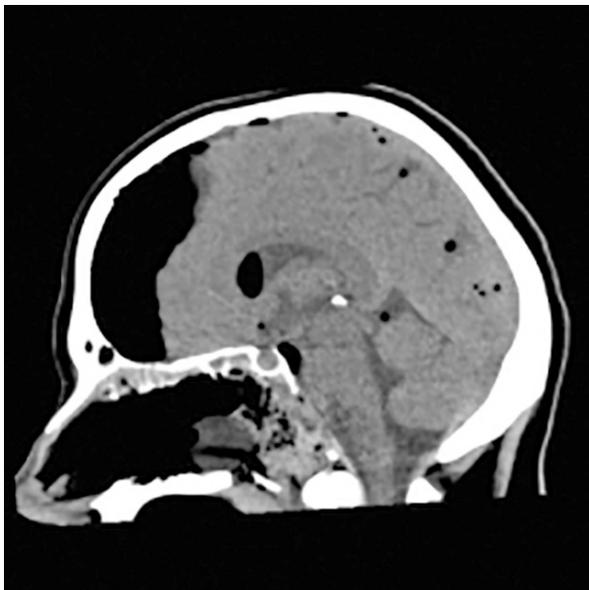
Post-operative head CT of the patient presented in Figure 1, which was taken on the first post-operative day. Most of the clivus has been resected due to the approach to the cyst. Pneumocephalus is seen, which did not manifest clinically and later spontaneously resolved.
